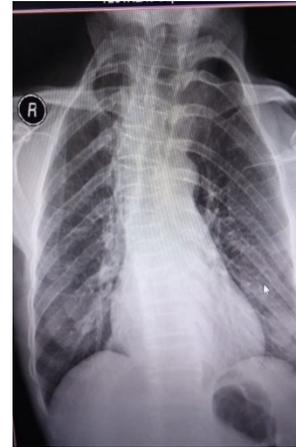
Chest X-ray of our patient showing thoracic scoliosis.
